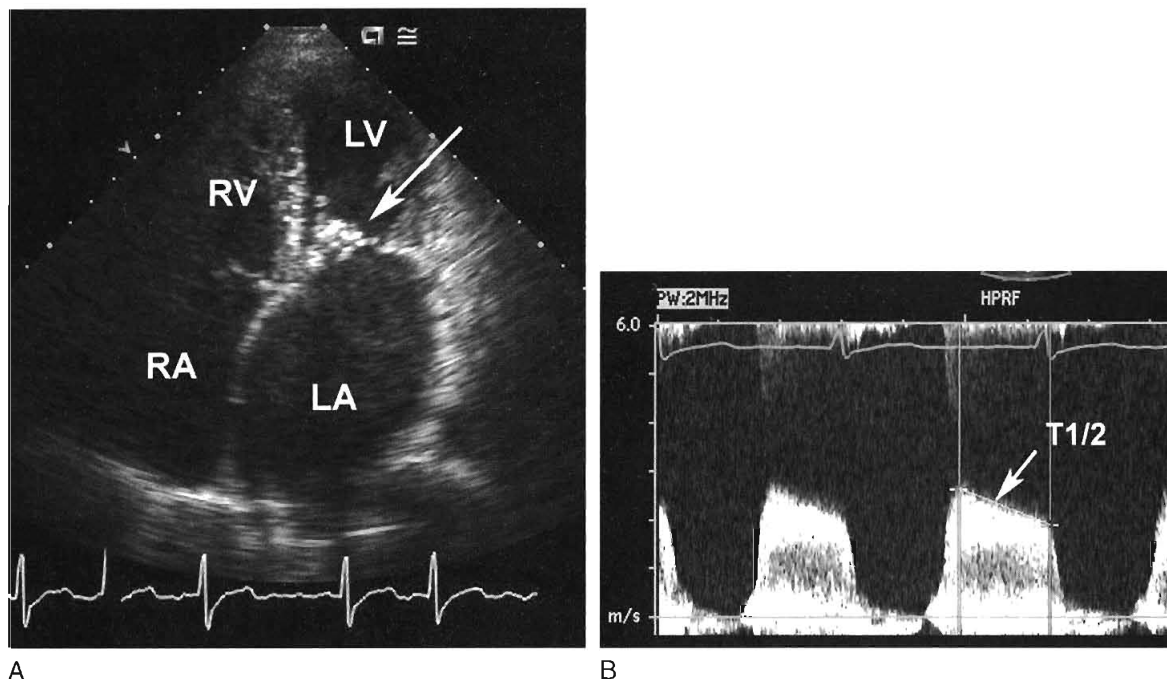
In the same patient as Figure 103-8, the apical four-chamber view (A) shows severe left atrial enlargement due to mitral obstruction with thickened valve leaflets (*arrow*). The haziness in the left atrium is due to stasis of blood flow with spontaneous contrast medium enhancement on echocardiography. Continuous wave Doppler recording of flow across the mitral valve (B) shows an increased velocity corresponding to the transvalvular pressure gradient. The pressure half-time (T1/2) can be used to accurately calculate mitral valve area (0.7 cm²).
